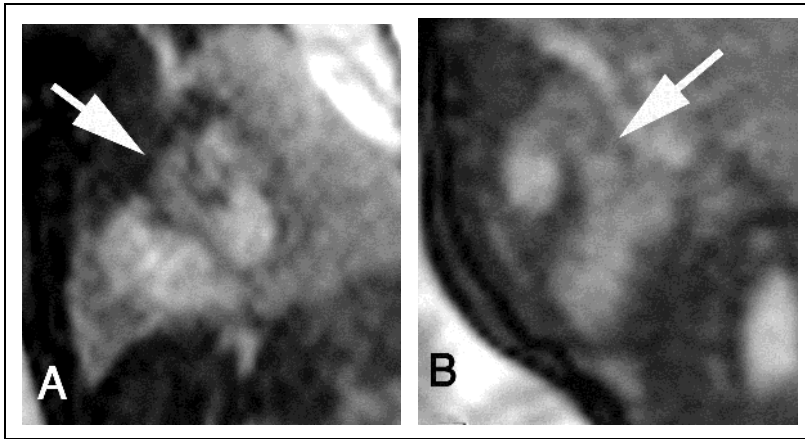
MRI anatomy of fetal heart at 28 weeks' gestation displayed in short cardiac axis (A) and two-cardiac chamber view along the left heart (B) using b-SSFP sequence. Arrows in both views point to left ventricular outflow tract originating from the left ventricle
